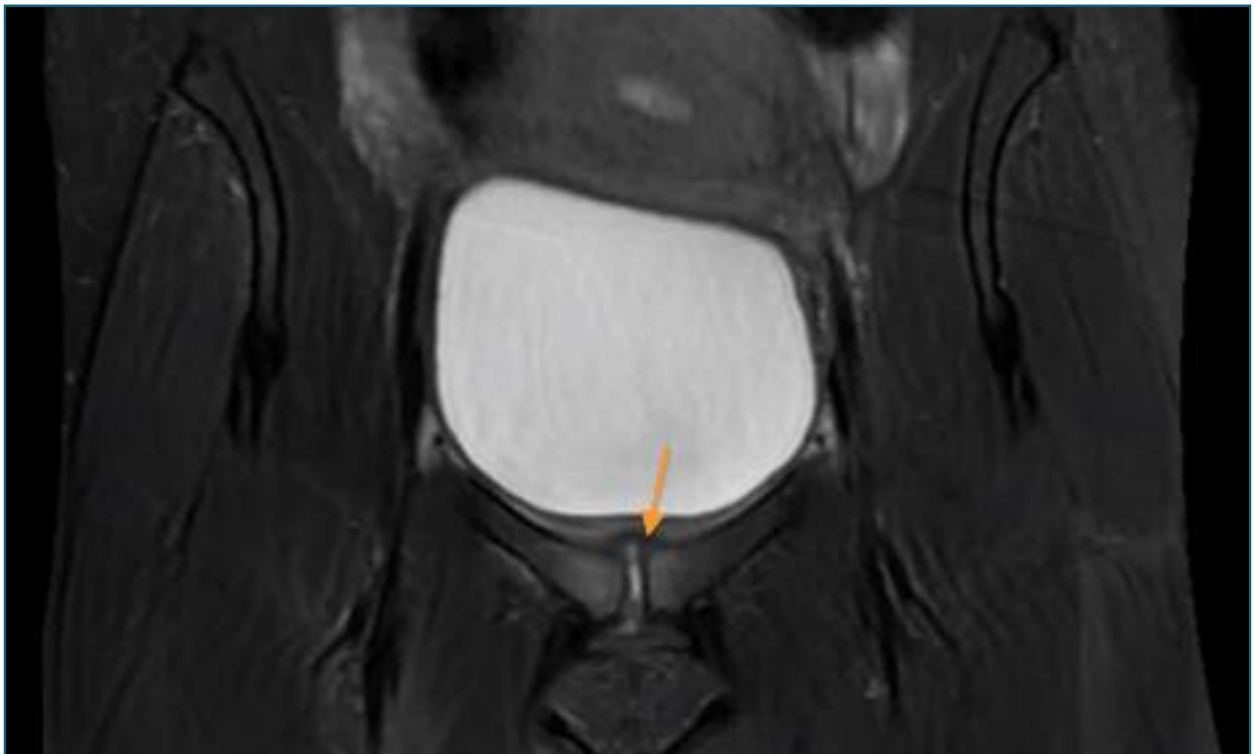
Pelvic MRI (coronal plane) – MRI showing hyperintense T2 signal and cortical irregularities on the articular surface and densifications of the soft tissues.
